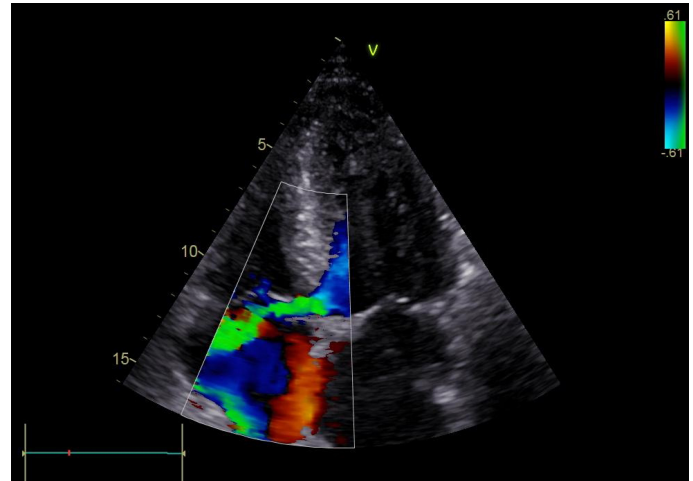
Shunt from the left ventricle to the right atrium was observed in systole with color Doppler examination in the apical 4-chamber image.
